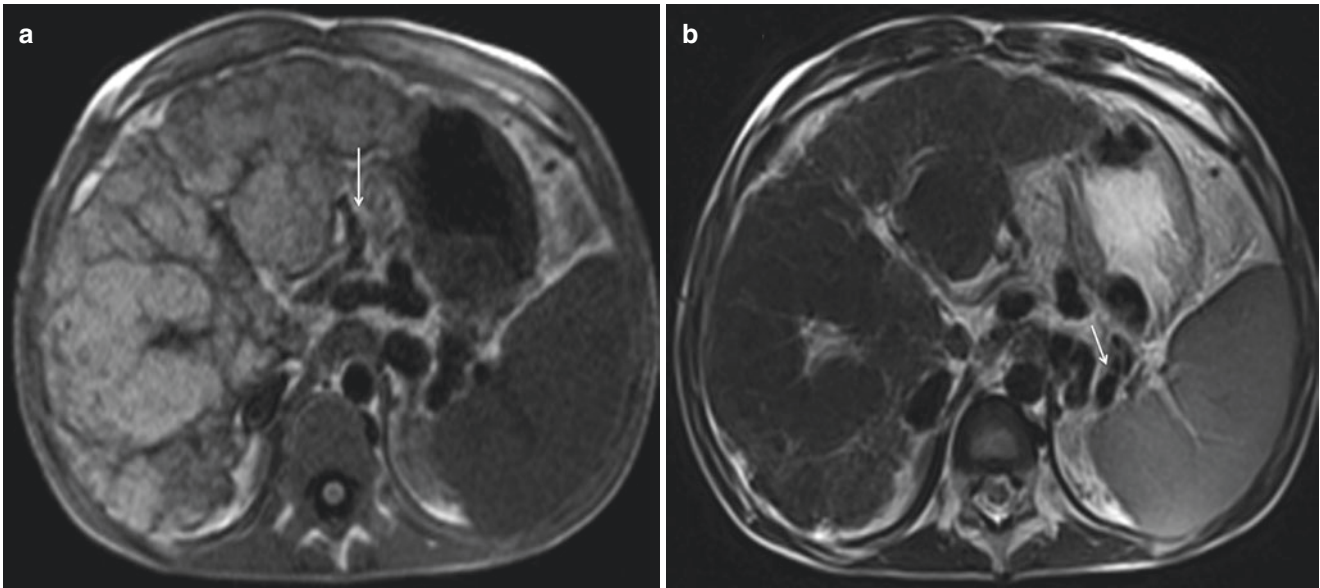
MRI T1W (a) and T2W (b) images of a cirrhotic liver with markedly abnormal contour and varying size-regenerative nodules throughout. The portal vein is occluded, and there are numerous short gastric and splenic varices (arrows)
